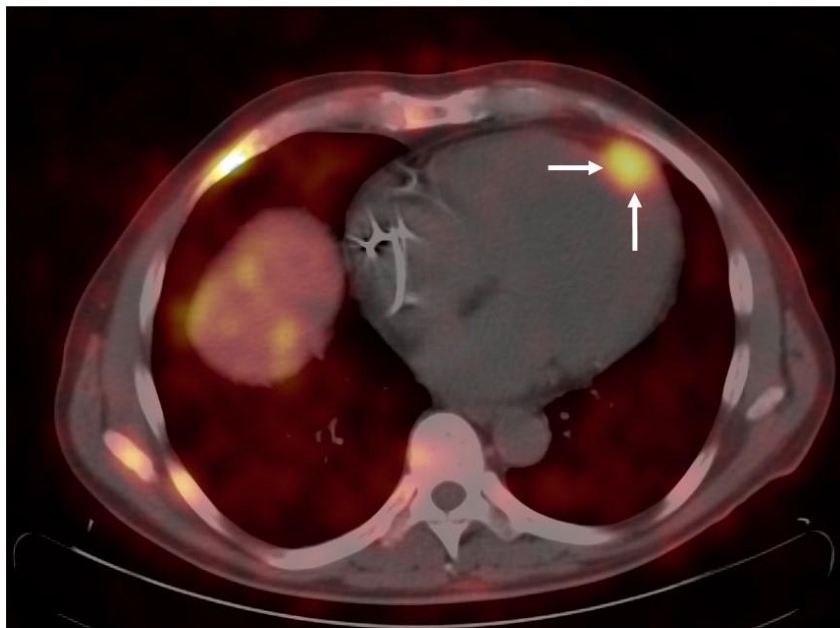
^{68}Ga -DOTANOC PET-CT scan showing intense somatostatin overexpression of the epicardial apical mass (White arrows).
